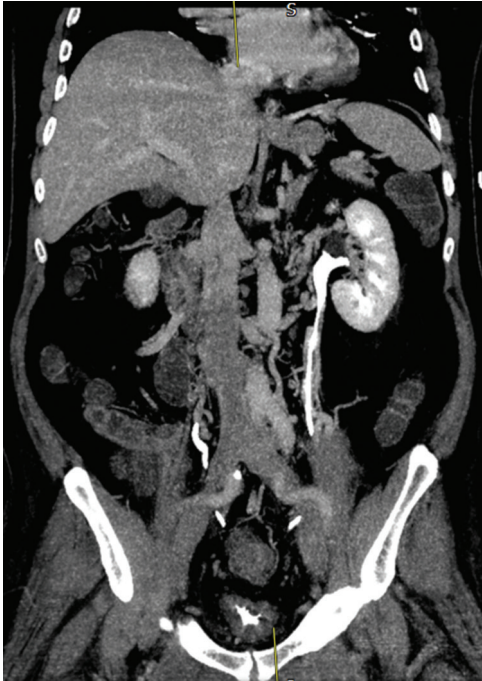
Coronal CT image demonstrating IVC thrombosis.
